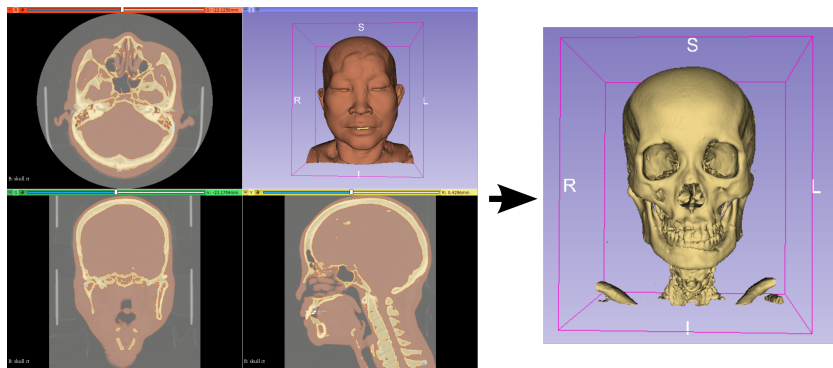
Example of a CT scan segmented using the software 3D Slicer. Medical imaging was used with the consent of the patient who preferred to remain anonymous.
